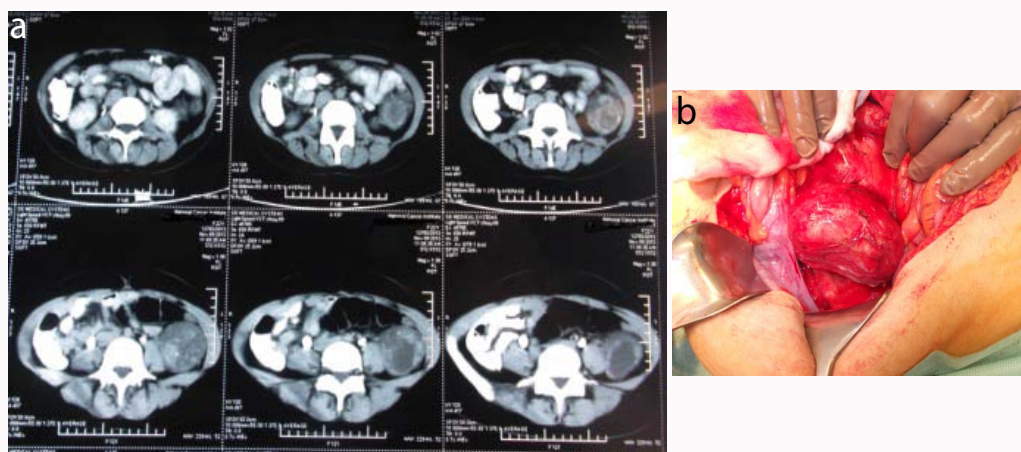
Patient 7 in Table 1. a) Surveillance CT lower abdomen of the lady 49 month after surgery shows the second recurrence of schwannoma in the left paracolic gutter. b) 3rd abdominal exploration to resect 9 cm recurrence.
